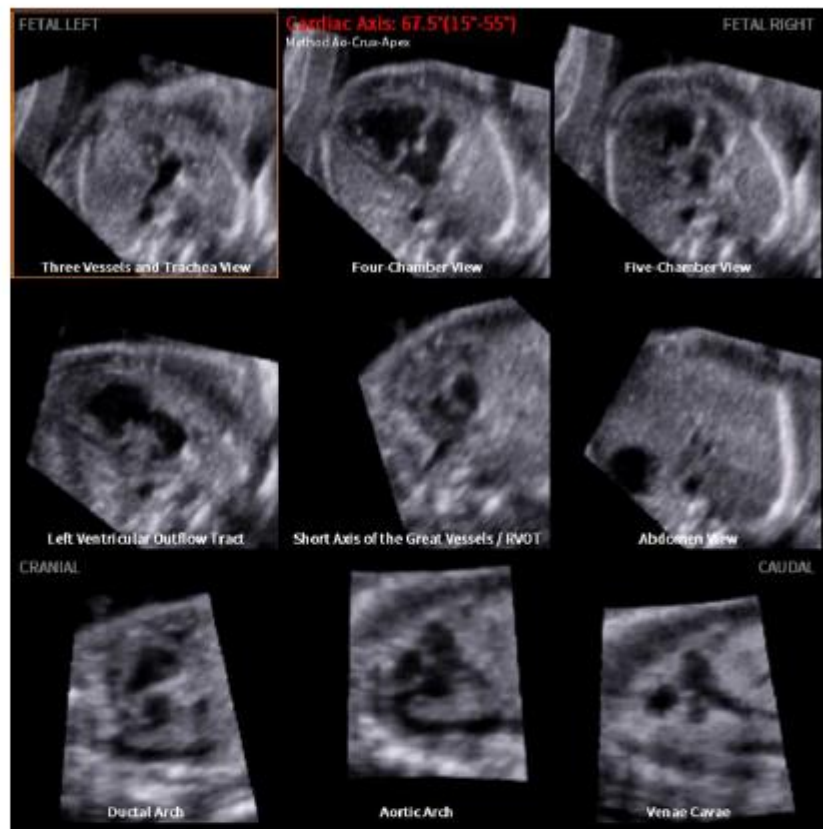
Example of fetal intelligent navigation echocardiography (FINE): the images display a fetus’s heart with a double inlet left ventricle (DILV) and pulmonary valve atresia, with a computerized cardiac axis of 67.5°. All nine planes are depicted (from left to right): three vessels and trachea view—with an absent truncus pulmonalis, four-chamber view—with the absence of the ventricular septum, five-chamber view, left ventricular outflow tract, the short axis of the great vessels (right ventricular outflow tract)—with an absent truncus pulmonalis, abdomen view, ductal arch—which does not become visible, aortic arch and venae cavae.
